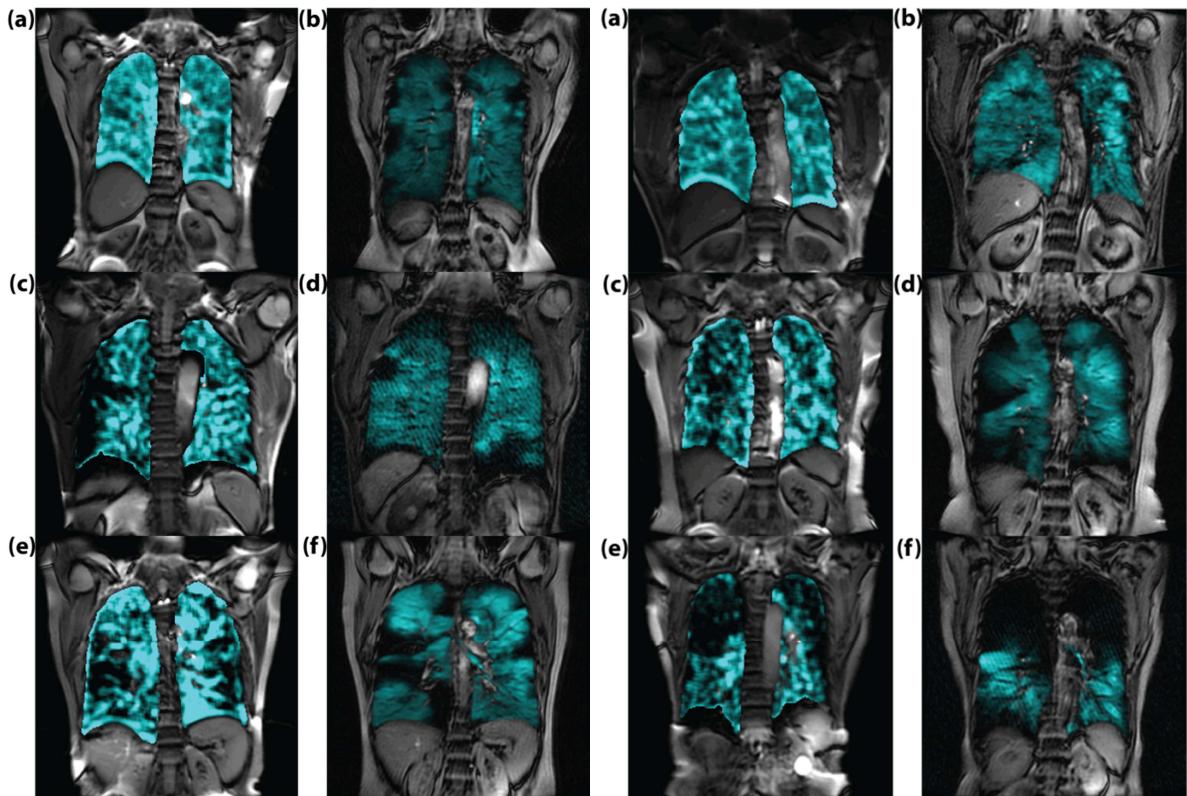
GOLD Stage I a) FDMRI, b) ^3He MRI; GOLD Stage II, c) FDMRI, d) ^3He MRI; GOLD Stage III e) FDMRI, f) ^3He MRI.
